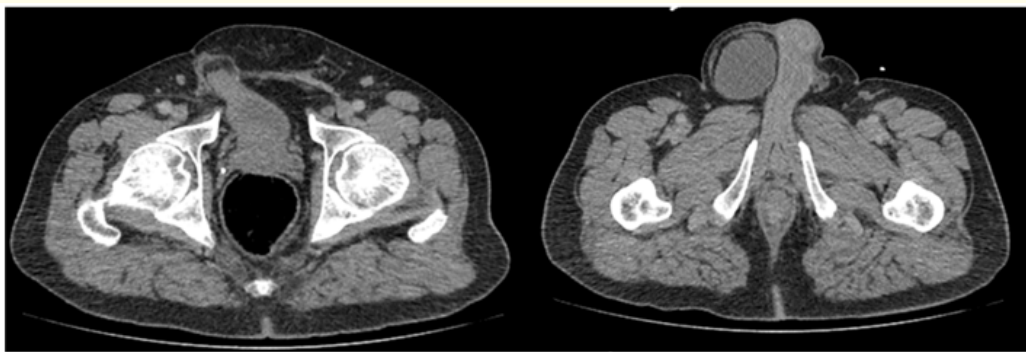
Axial contrast-enhanced CT of the abdomen and pelvis: herniation of the right lateral bladder wall through the right deep inguinal ring, consistent with a right inguinal bladder hernia. No evidence of associated wall complication.
